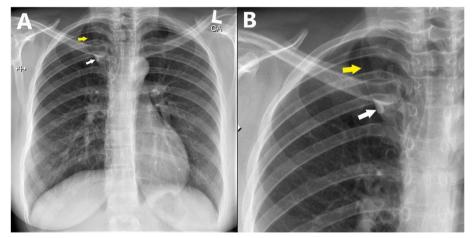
a, b Chest radiograph of normal azygos lobe and fissure. a Frontal chest radiograph demonstrates the azygos fissure (yellow arrow) and azygos vein (white arrow). b Magnified image of the same radiograph demonstrates the azygos fissure (yellow arrow) and the tear drop shape of azygos vein (white arrow)
